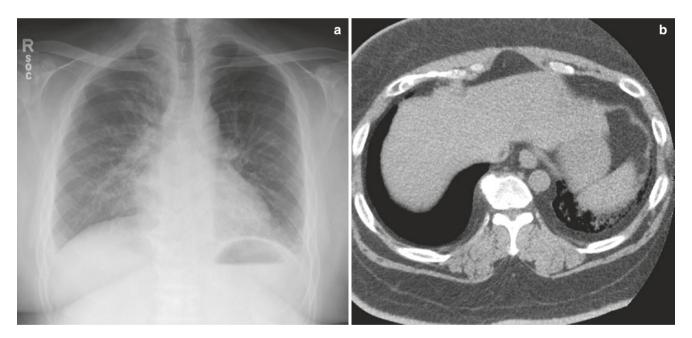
Extrapleural fat mimicking pleural effusion. (a) Frontal chest radiograph shows blunting of the costophrenic angles. Note the opacity over the angles is of low attenuation (ground glass), the sharp
